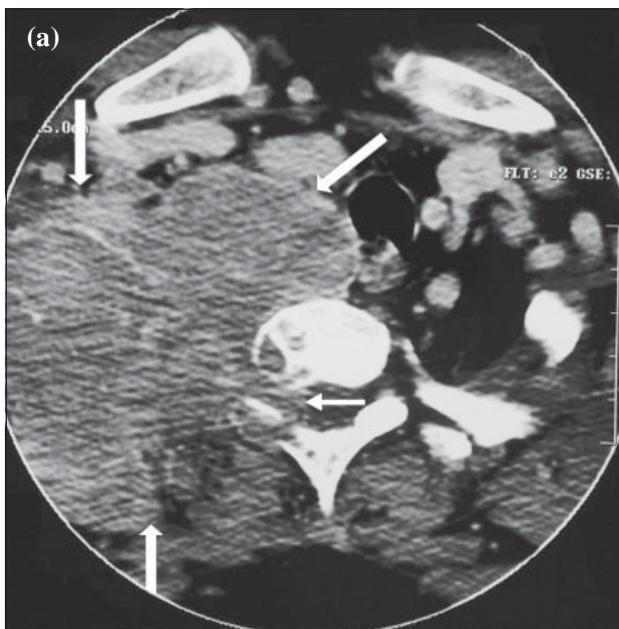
Computed tomography images at T1 level. (a) Viewed using soft tissue window settings, the size of the lesion (thick arrows), with extension into the intervertebral foramen and thecal sac compression (thin arrow) can be seen; (b) viewed using bone window setting shows vertebral body, right transverse process, pedicle, and lamina destruction (thick arrows). A thin shell of posterior calcification within the mass (thin arrow) is also shown.
